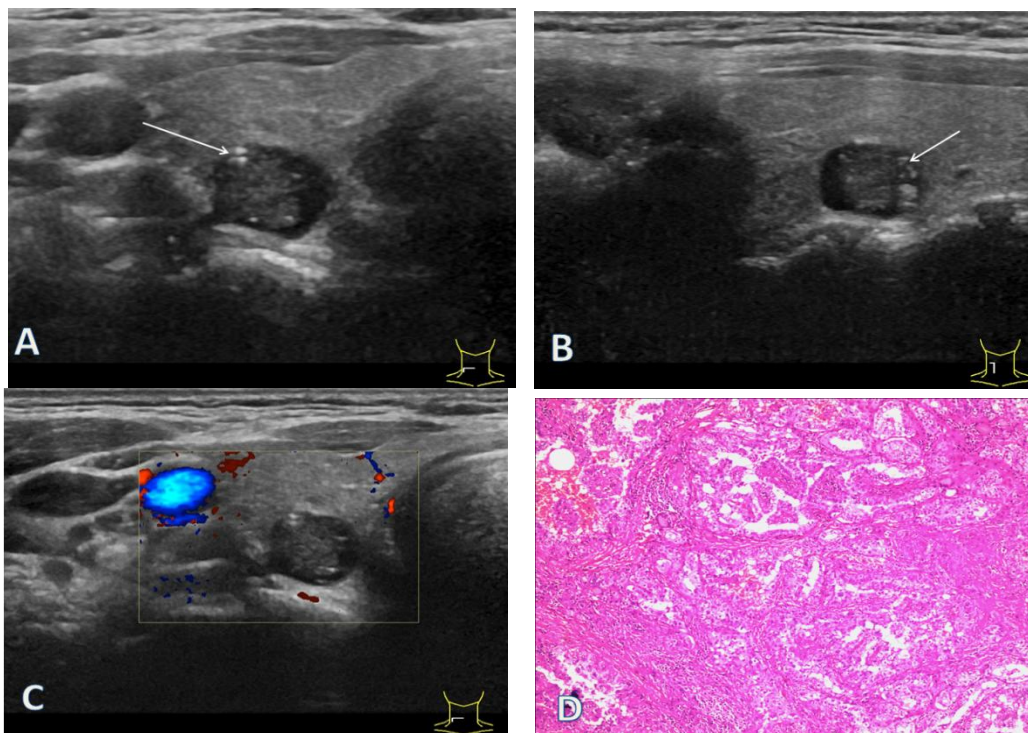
Ultrasonography of PTC combined with cystic changes in a 35-year-old female patient.
